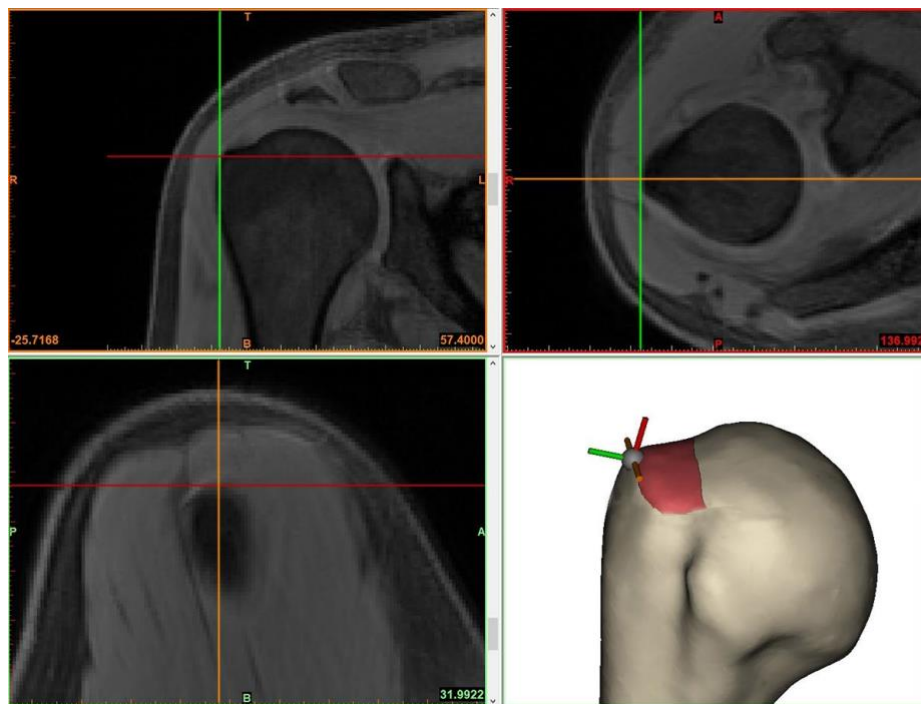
Identification of rotator cuff insertion region of interest. The crosshairs on the three MR views indicates the 2D location of the reference marker (ball with crosshairs) on the 3D humeral model. The margin of the rotator cuff insertion was identified by scrolling through the slices of each MR view and ensuring the margins of the insertion as seen on the MR images are consistent between the reference marker and insertion region of interest (red surface) on the 3D model.
